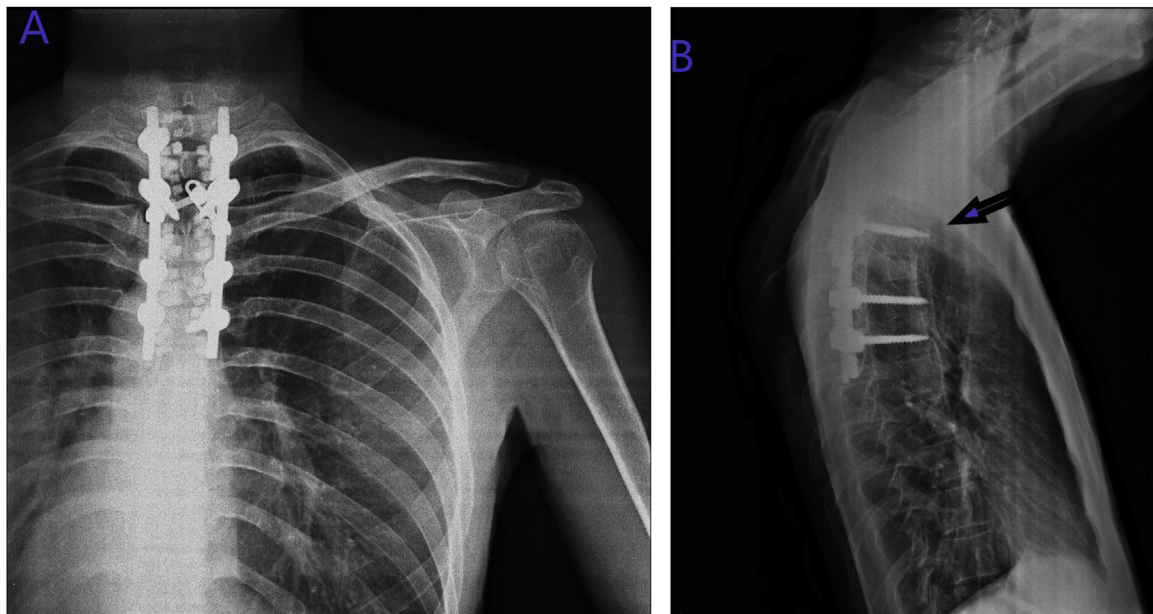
On the 2nd postoperative day, the patient's direct radiography has taken (A). One of the screws that were sent to T3 was long (Arrow) (B).
